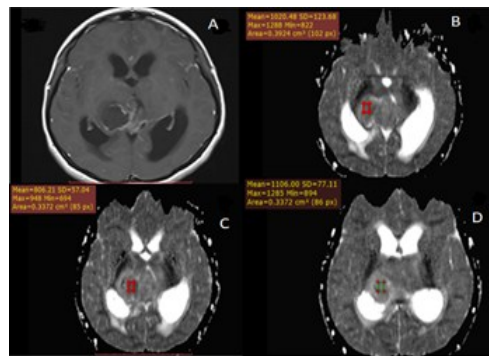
presents the case of an 11-year-old female patient diagnosed with medulloblastoma. The diagnosis was established based on routine sequences and post-contrast axial T1-weighted imaging (T1WI) (A). In this analysis, three distinct regions of interest (ROI) were strategically positioned away from areas displaying necrosis or hemorrhage within the tumor. These ROIs were carefully selected on three consecutive slices of the apparent diffusion coefficient (ADC) map (B, C, and D). The RadiAnt DICOM viewer was utilized to perform an automatic calculation of the mean, minimum, and maximum signal intensity values within the ADC map.
